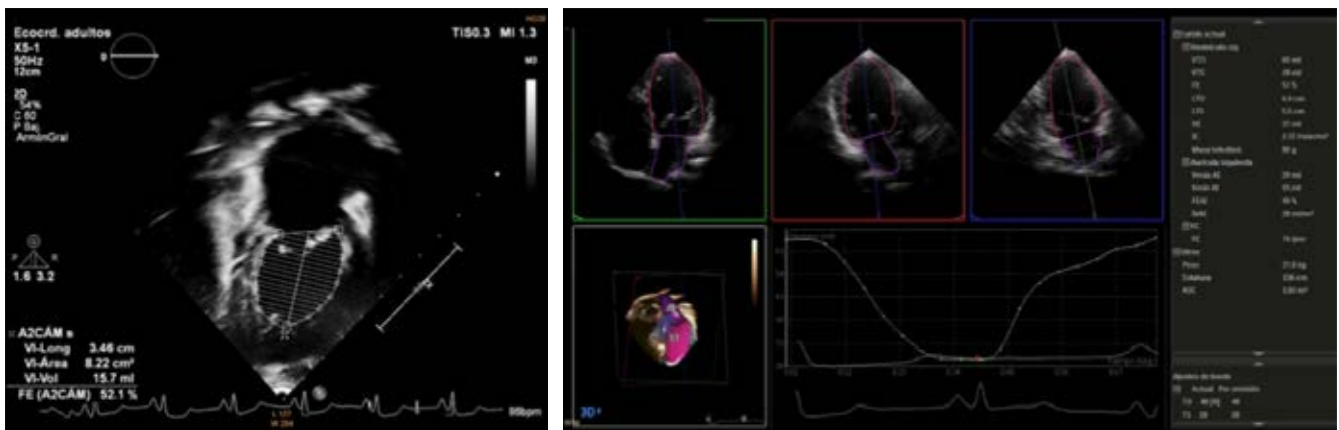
November 2021 Echocardiography with a significant improvement in left ventricular function: Left Ventricular Ejection Fraction (LVEF) increased to 52%.
